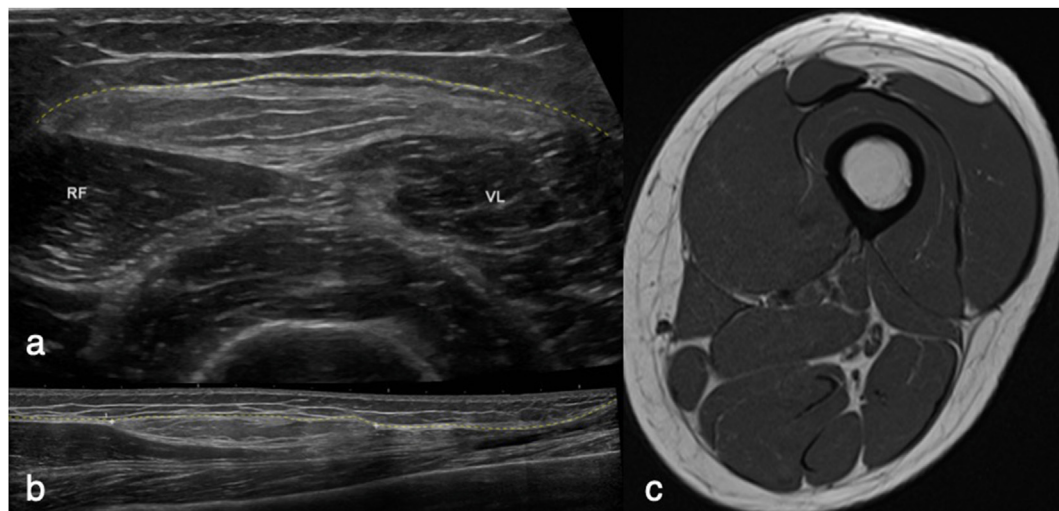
Deep lipoma. A transverse ultrasound view through the left anterior upper thigh (a) reveals a lipoma deep to the deep fascia (broken yellow line) and superficial to the rectus femoris and vastus lateralis muscles. A longitudinal ultrasound view (b) again demonstrates the lipoma just deep to the deep fascia (broken yellow line). An axial T1W image through the left upper thigh (c) confirms the lipoma.
